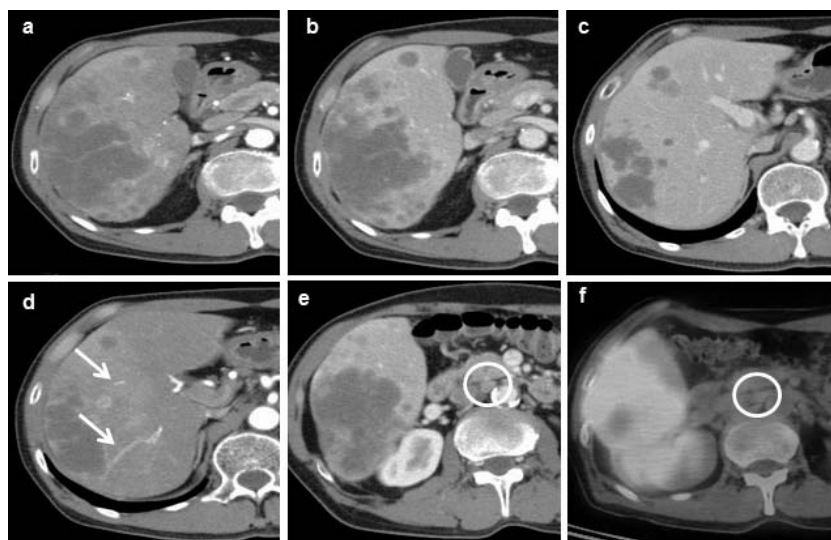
CT findings. (a) The tumor was enhanced at the periphery during the early phase. (b) From the portal phase to the delayed phase, the tumor exhibited homogeneous enhancement relative to the normal liver. The inside of the tumor was not enhanced. (c) The infiltration to the main portal vein was not evident. (d) Vessel penetration into the tumor was observed from the early phase to the portal phase (arrows). (e and f) Para-aortic lymph node swelling was observed (circle), but did not exhibit uptake of ^{18}F -fluorodeoxyglucose.
